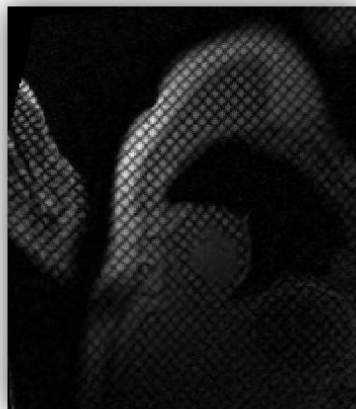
Example of a cardiac SPAMM MRI image from the database and the respective grid.
